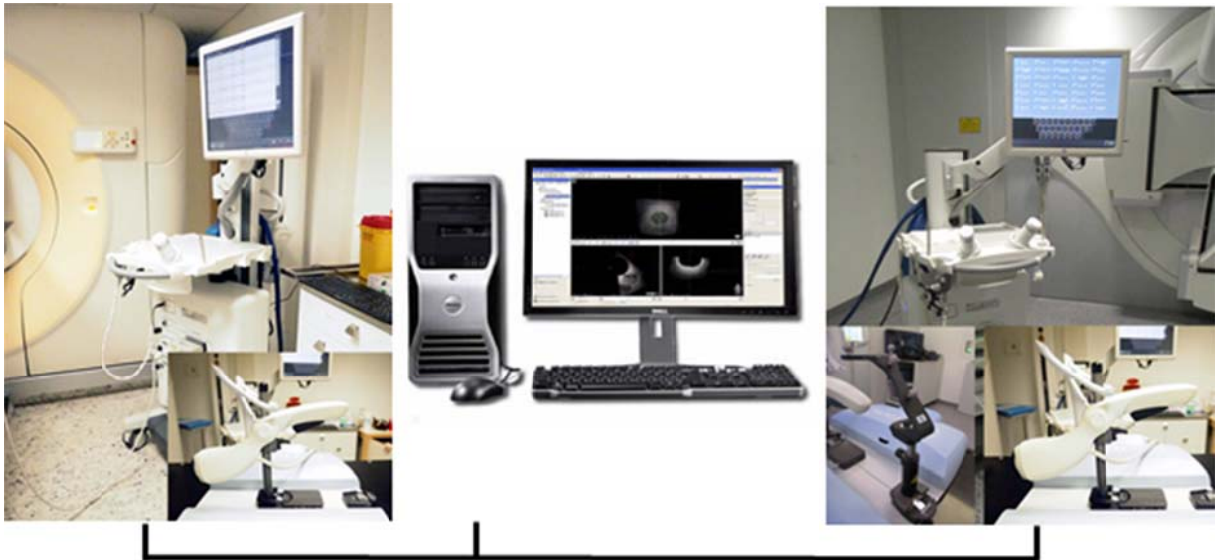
Clarity AutoscanTM (Elekta AB, Stockholm, Sweden) system configuration, Clarity-Sim in Planning-CT room equipped with TPUS Autoscan probe (left) connected via DICOM network to Clarity workstation (server) (middle) and Clarity-Guide in treatment room equipped with TPUS Autoscan probe and Couch Position Indicator (CPI) (right)
